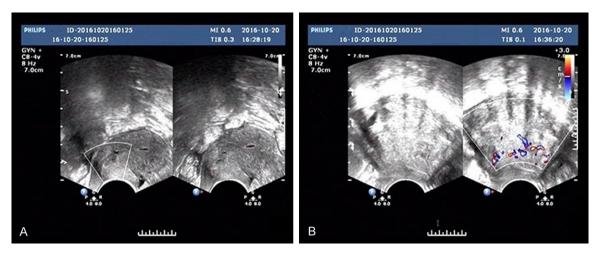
Transvaginal ultrasonography: A. A 44 mm × 43 mm × 51 mm mixed echoic mass on the right wall of vaginal wall. B. The inner construction is even with abundant blood flow signals.
